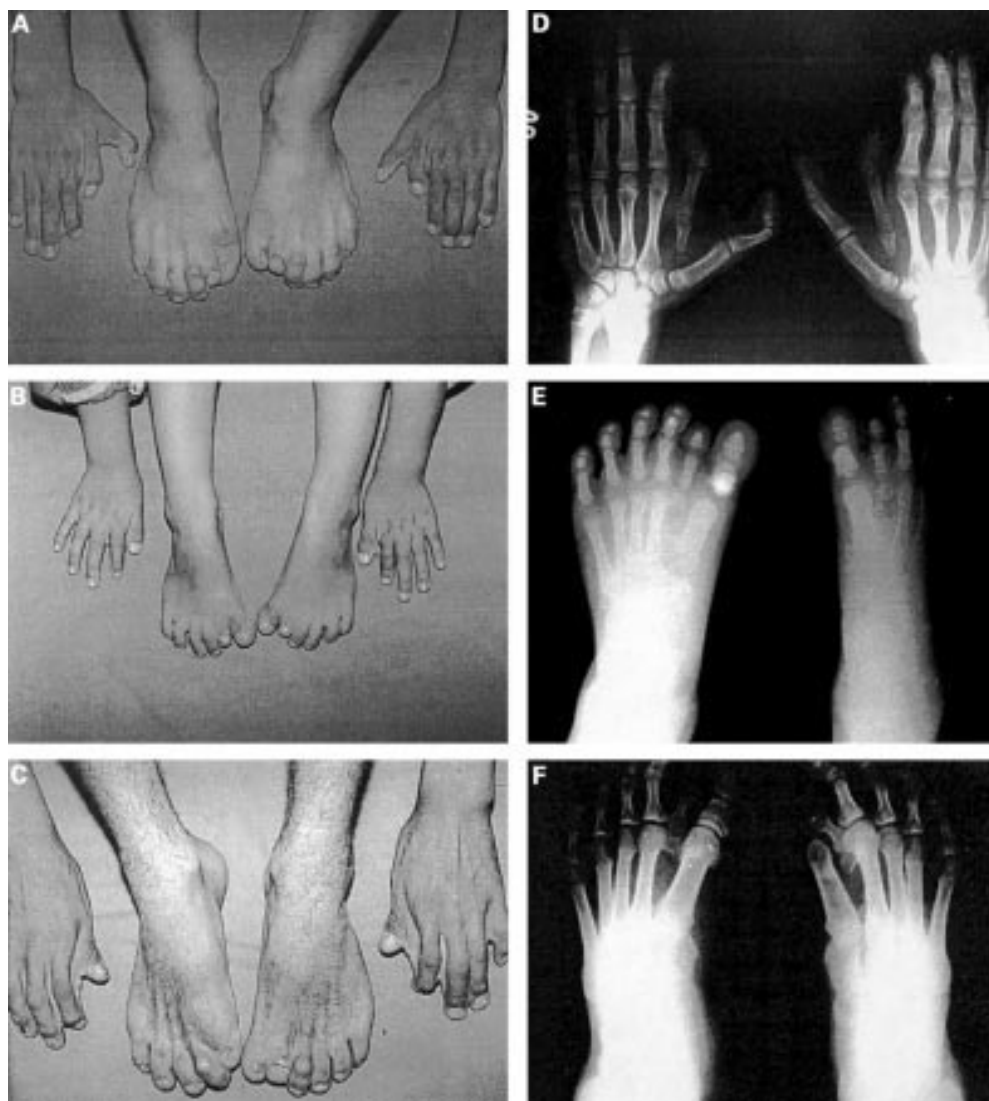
Limb abnormalities in three typically affected subjects. Hand and foot photographs of (A) V.34, (B) VI.21, and (C) V.58, showing partial or complete skin syndactyly between all digits of all four limbs, preaxial polydactyly in the feet, and, in V.34 only, preaxial polydactyly in the hands. (D) Radiograph of the hands of V.34, showing bilateral triphalangeal thumbs and bilateral extra triphalangeal digits with rudimentary extra metacarpals in the first web spaces. (E) Radiograph of the feet of VI.21, showing bilateral, small, extra biphalangeal digits with rudimentary extra metatarsals in the first web spaces. (F) Radiograph of the feet of V.58, showing bilateral rudimentary extra digits in the first web spaces, and, on the left, absence of both phalanges of the hallux, with hypoplasia of the head of the first metatarsal.
